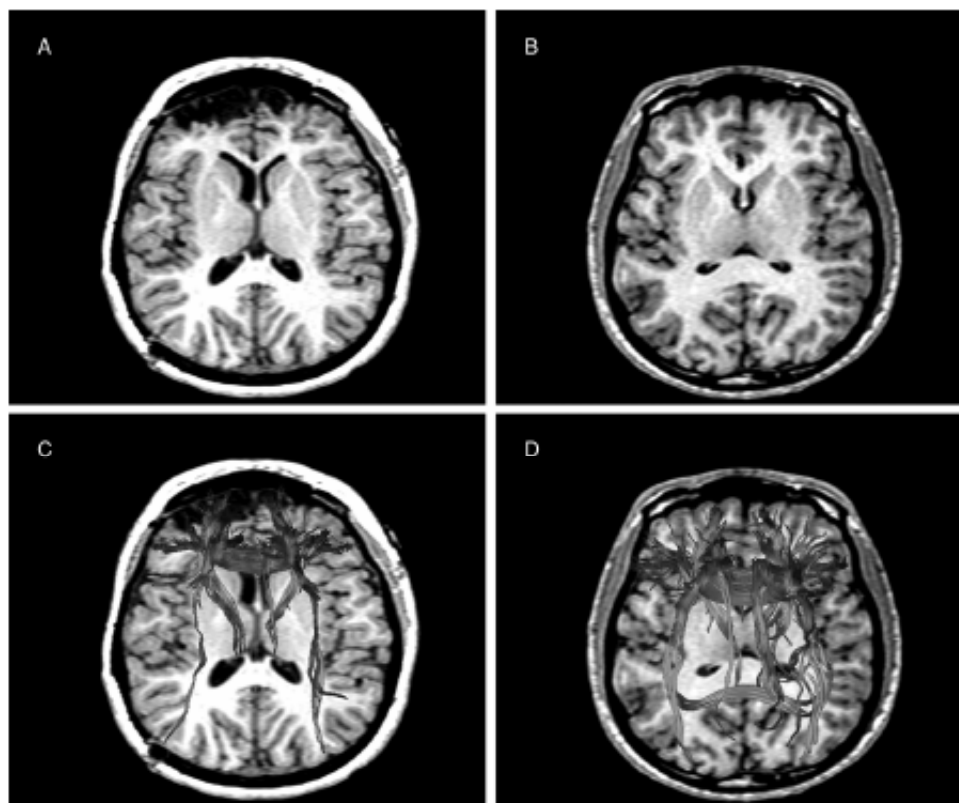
DTI demonstration of loss of tracts in a child with brain injury where conventional MRI shows massive frontal encephalomalacia as depicted in (A) (dark signal involving both frontal poles) as compared to the age-matched control in (B). (C) shows the effects of the frontal damage on the tracts associated with frontal projections, which are markedly reduced in (C) compared to the control in (D). Please see Plate 4 for color figure.
